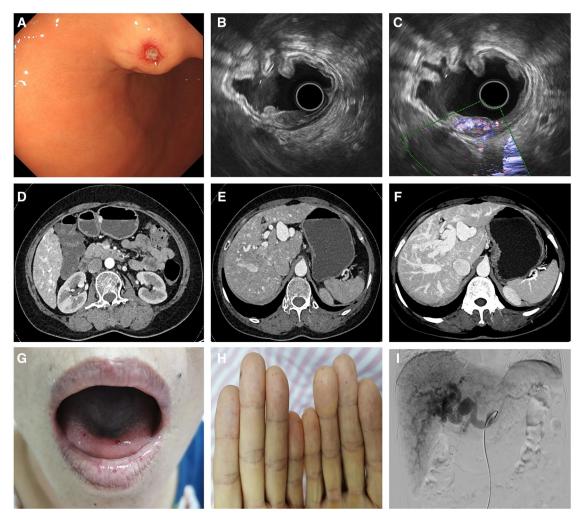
Clinical data of the case with hereditary hemorrhagic telangiectasia. (A-C) Endoscopy and endoscopic ultrasound showed a submucosal prominence at the lesser curvature of the stomach. (D-F) Contrast-enhanced computed tomography showed an enhanced vessel sign at the lesser curvature of the stomach, tortuous hepatic arteries, aneurysmal dilatation of the proper hepatic artery, along with precocious visualization of hepatic veins, indicating a hepatic arteriovenous fistula. (G and H) Multiple telangiectasias were found on the tongue, lips, and fingertips. (I) Celiac trunk angiography revealed tortuous hepatic arteries and aneurysmal dilatation of proper hepatic artery and specifically showed a cluster of tortuous small vessels at the lesser curvature of the stomach.
